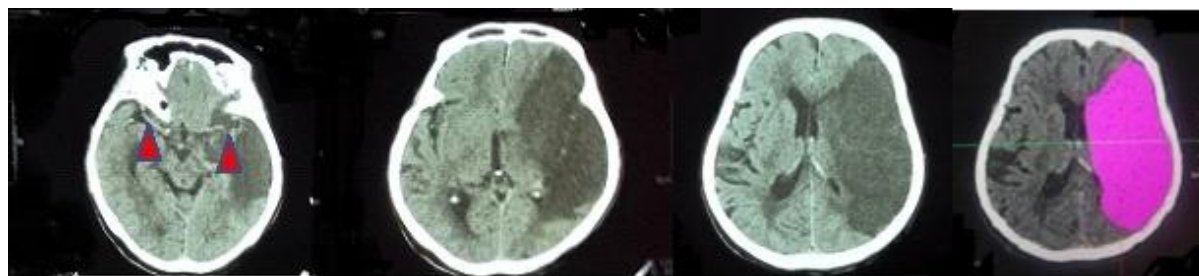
Non contrast CT done on presentation to emergency ward showed there was hyperdens sign in right and left M1 (see red arrowhead) (A), loss of differentiation of grey and white matter in the left MCA area (B) and herniation > 5mm to the right, there was effacement of sulci and gyri in the left hemisphere (C). Using CT scan manual tracing software, it was measured infarct volume 232 cm³.
